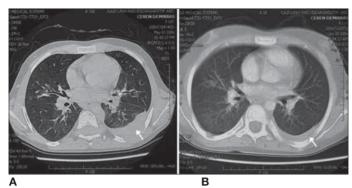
A. Axial CT scan showing a large pleural-based soft tissue lesion with regular contours in the upper lobe of the left lung; B. Control CT examination shows a significant decrease in the size of the lesion
